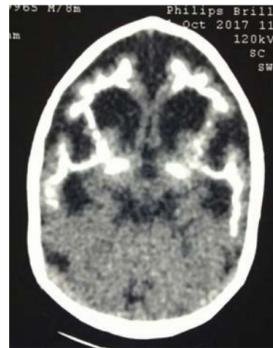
Brain CT scan with subcortical calcifications
